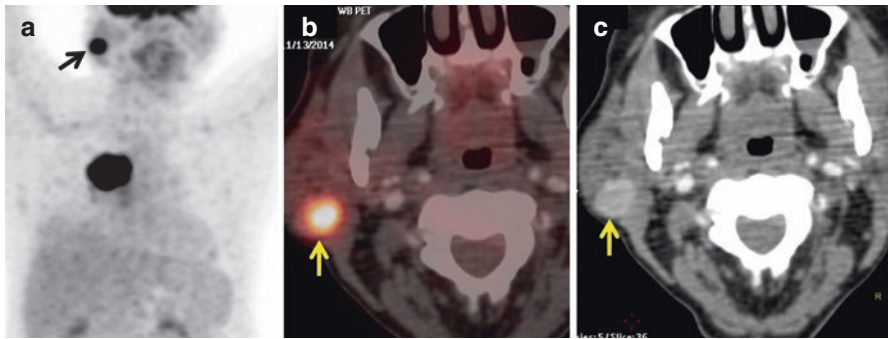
FDG PET/CT scan done in a 60-year-old gentleman with poorly differentiated non-small cell carcinoma in the upper lobe of the right lung (MIP a). The scan shows enhancing FDG-avid nodule in the right parotid gland (arrow in a–c). Though the imaging findings were favoring the possibility of a benign Warthin’s tumor, a biopsy was advised in view of the poorly differentiated nature of the tumor. Biopsy confirmed Warthin’s tumor in the right parotid gland
